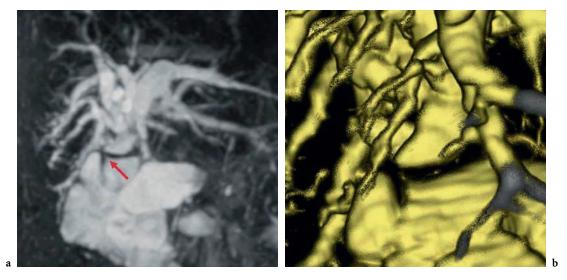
Stenosis of hepaticojejunostomy. Coronal oblique MIP 3D heavily T2-weighted MR cholangiogram (a) and MR VR enlargement (b) accurately depict an anastomotic stricture (*arrow*) with marked dilation of the pre-anastomotic extra and intrahepatic biliary systems
